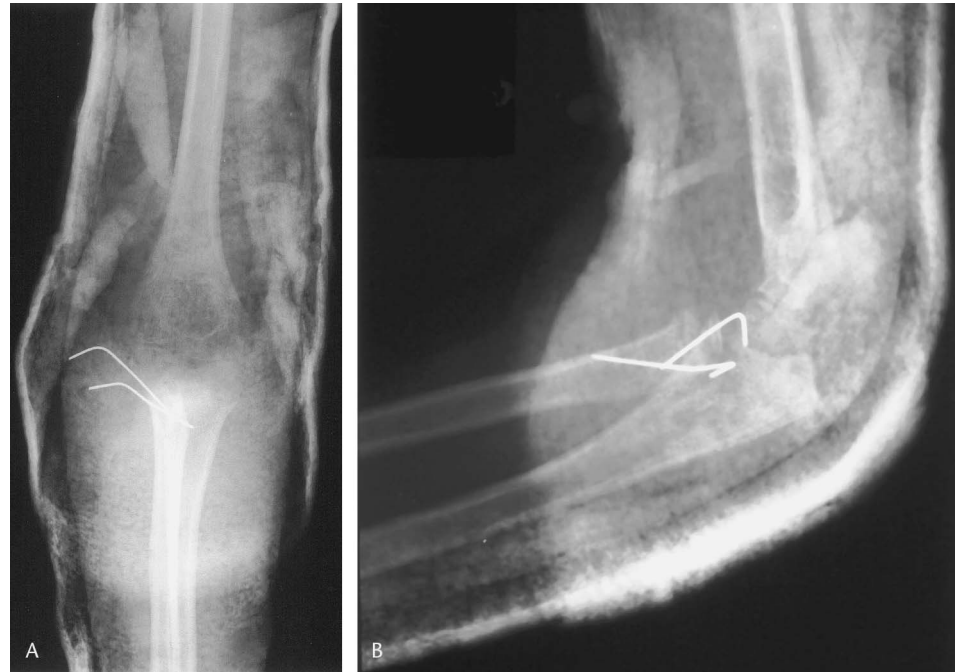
Anteroposterior (A) and lateral (B) radiographs obtained 7 days postoperatively confirming anatomic alignment and reduction of the radial head and radial neck fracture fixation with 2 K-wires.
